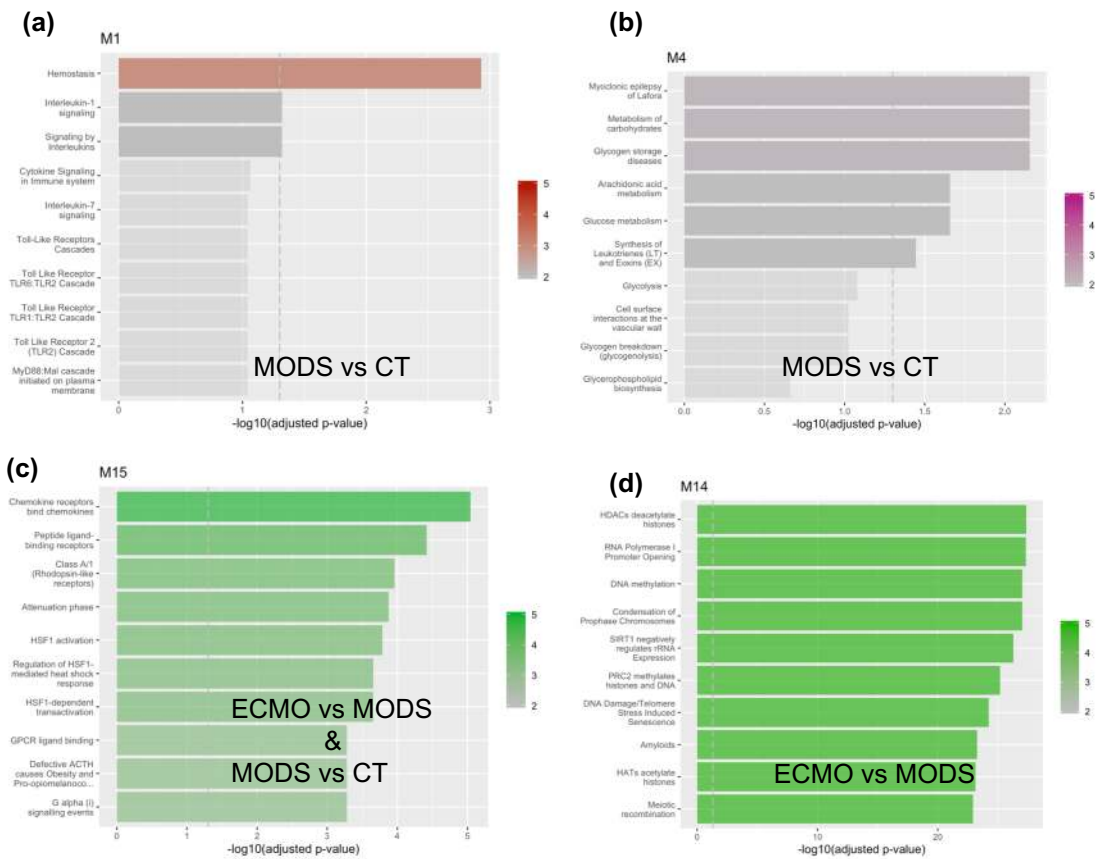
Pathways enriched by the genes present in different co-expressed networks module. (a, b) Enriched pathways are shown by the DE genes from MODS vs CT and mapped on two co-expressed networks. (c) Enriched pathways shared by the DE genes in MODS vs CT and in ECMO vs MODS are shown. This showed the transition from MODS to ECMO. (d) In addition, epigenetic modifications related processes were activated in the severe MODS patients, who require ECMO support.
